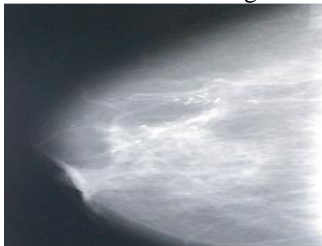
An X-ray mammography image with microcalcification areas.
